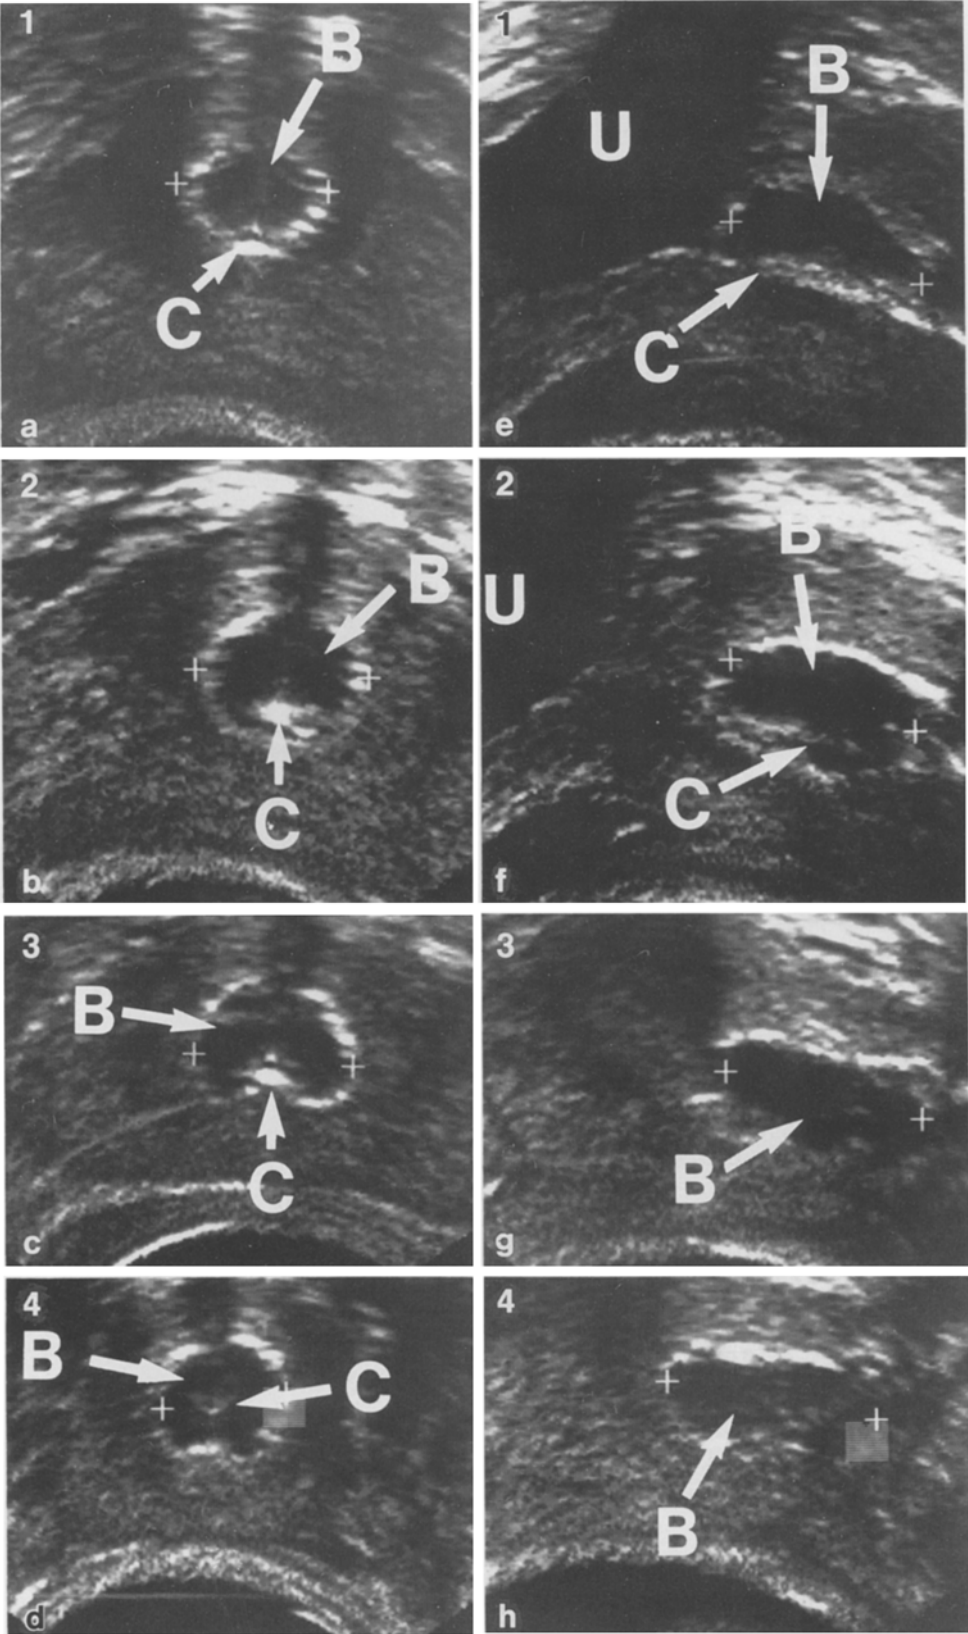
Rectal ultrasonography in a 32-year-old volunteer. The *left pictures (a-d)* are transverse sections and the *right pictures (e-h)*, longitudinal sections. The distance from the bladder neck is indicated in cm in the *left upper corner* of the pictures. *C*, Catheter; *B*, balloon; *U*, bladder
